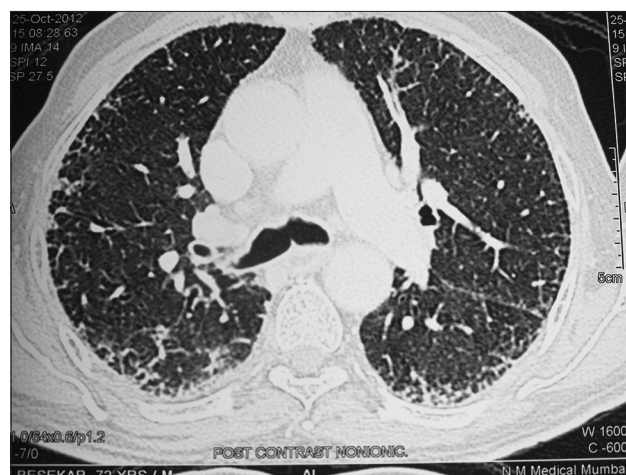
Pretreatment computed tomography scan chest, coronal view
